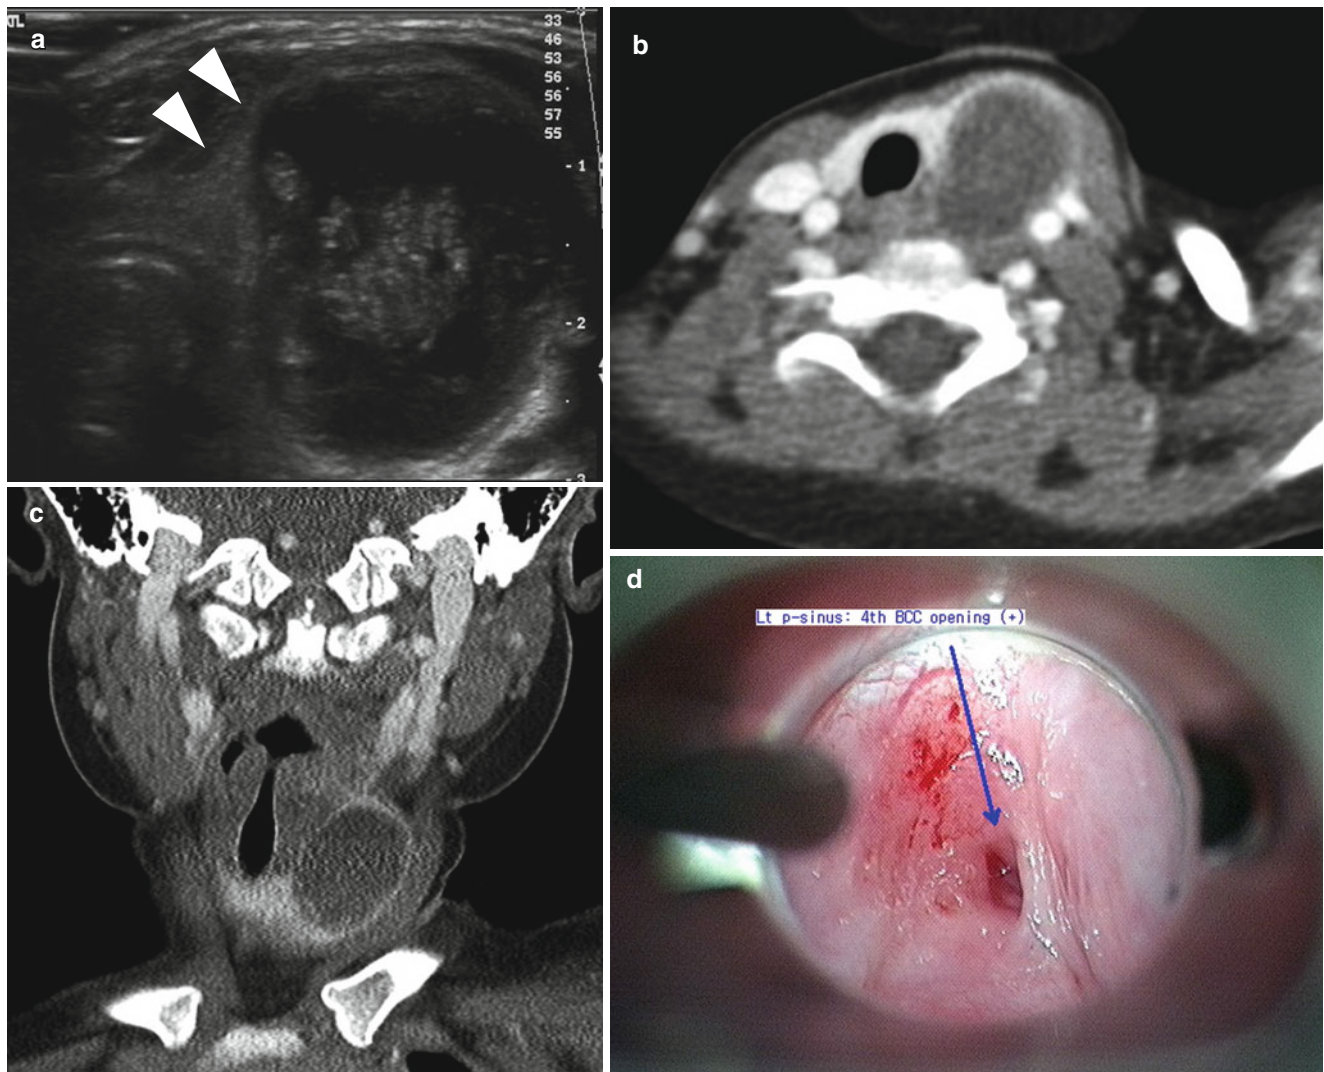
Pyriform sinus fistula with thyroid abscess. (a) Ultrasound of the thyroid gland shows mainly cystic mass with internal debris in the left thyroid lobe. There is a beak-like appearance of the left thyroid tissue (*arrowheads*) around the cystic mass. (b, c) Postcontrast axial (b)
